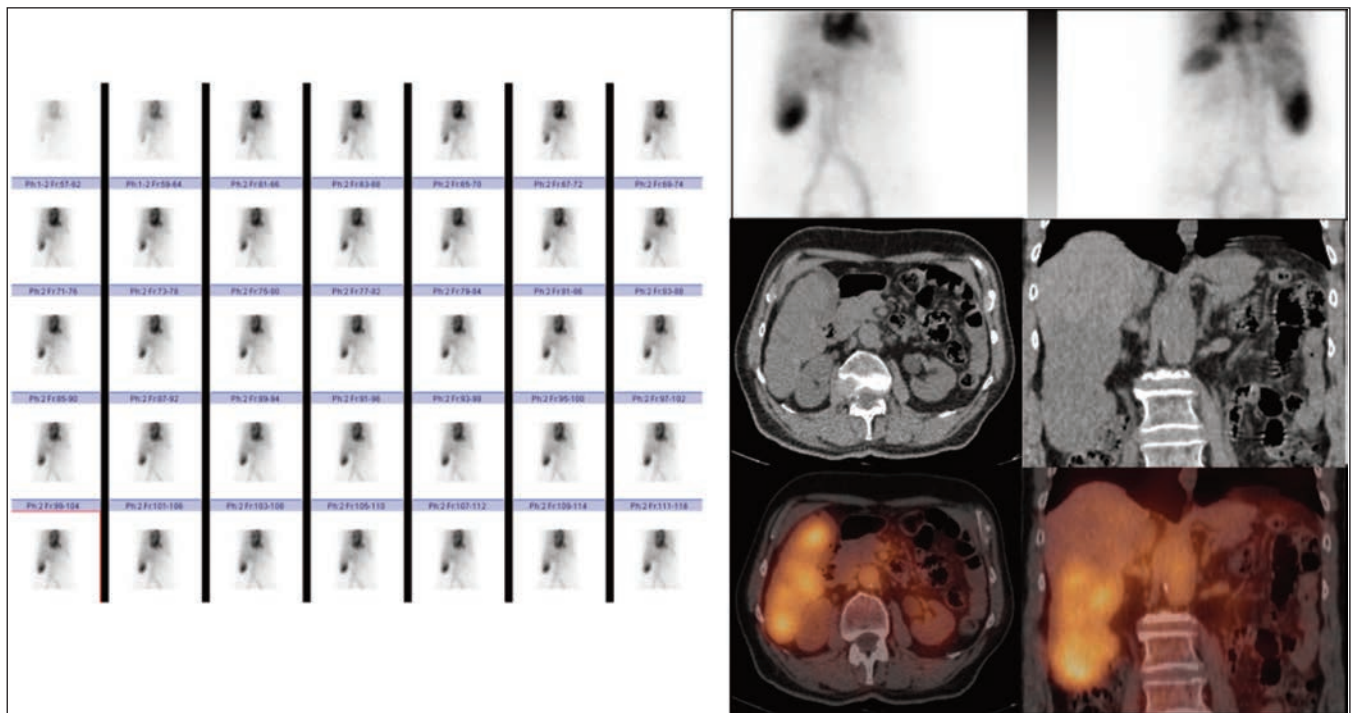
Initial dynamic (A) and static images (B) show focal increased tracer uptake in hepatic segment VI/VII (B, green arrow). Unenhanced axial (C) and coronal (D) images showed an ill-defined avid involving segment VI/VII (green circle) which measured 10.3 cm in maximum dimensions. This lesion showed increased tracer uptake as seen on fused axial SPECT/CT (E) and coronal (F) images (green circles).
